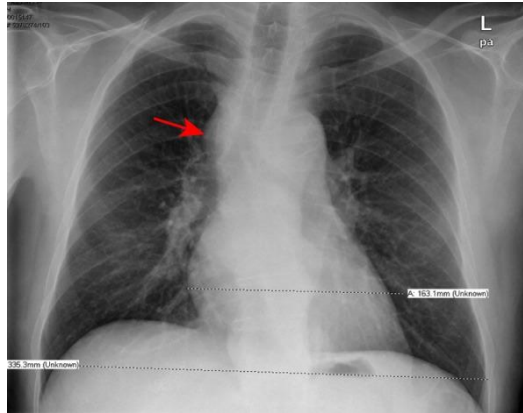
Chest X-ray showing superior mediastinal mass (red arrow). Reproduced from: [11] under the Creative Commons Attribution License.
